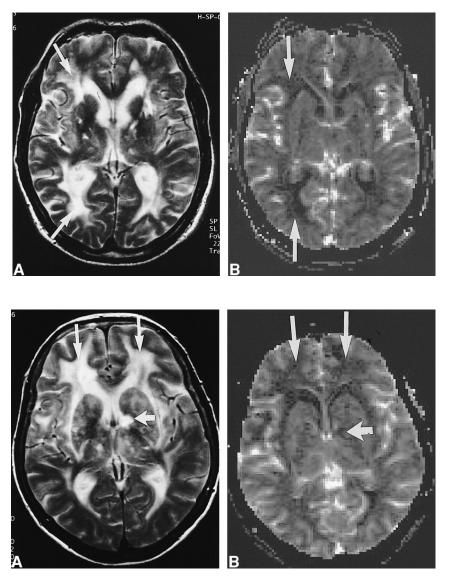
MR imaging findings of a 50-yearold man with CADASIL (MMSE score, 21; Rankin score, 1). *A*, T2-weighted image (2300/85/1). Lacunar defects (*one arrow*) and subcortical white matter abnormalities were detected (*two arrows*). *B*, rCBV map of the same section. Bilateral reduction of rCBV in the frontal lobes is visible on the rCBV map (*two arrows*). Lacunar defect visible on the T2-weighted image was also visible (*one arrow*). rCBV was calculated to be zero.
